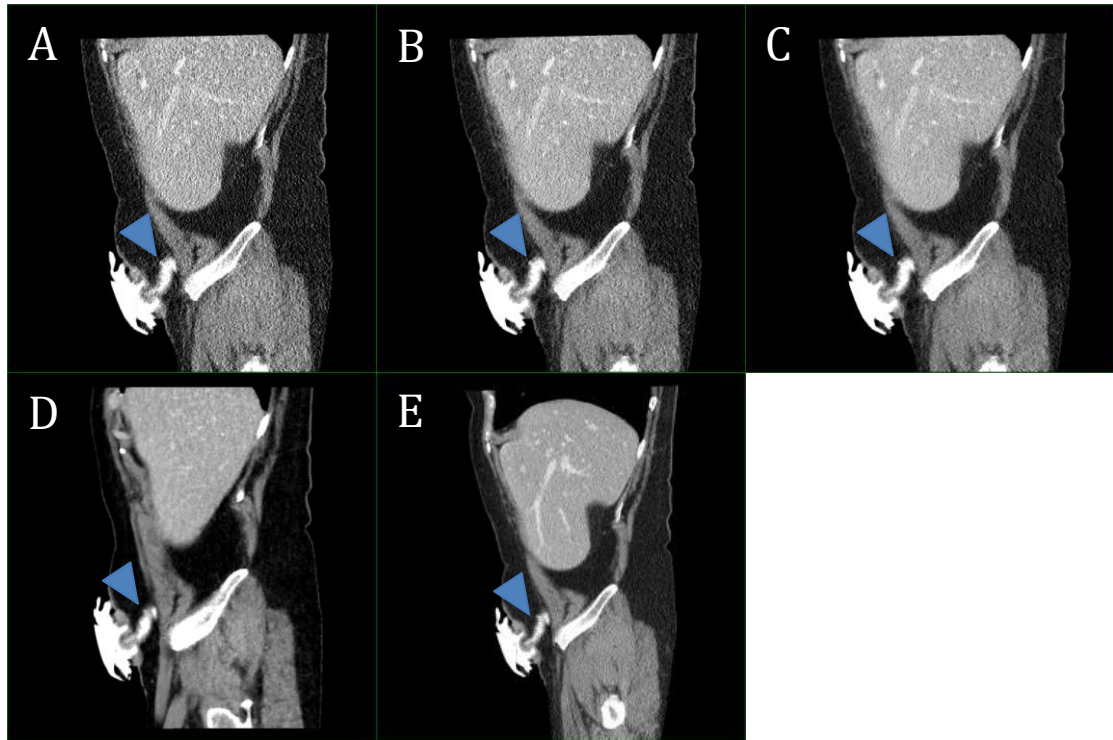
(A-E): Sagittal reconstructions of modified dose CT images with FBP (A), ASiR 40% (B), ASiR 70% (C) and MBIR (D) with conventional dose CT with FBP for comparison (E). Images demonstrate an uncomplicated end ileostomy in the right iliac fossa (blue arrowhead) in a 68 year old lady with a BMI of 22.8 kg/m². The modified dose CT was acquired at 1mSV and the conventional dose CT at 3.7mSV.
